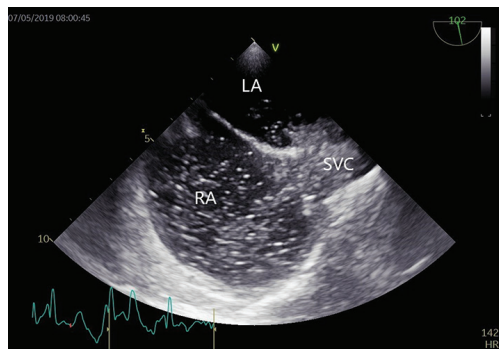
Transthoracic echocardiography with contrast study.
